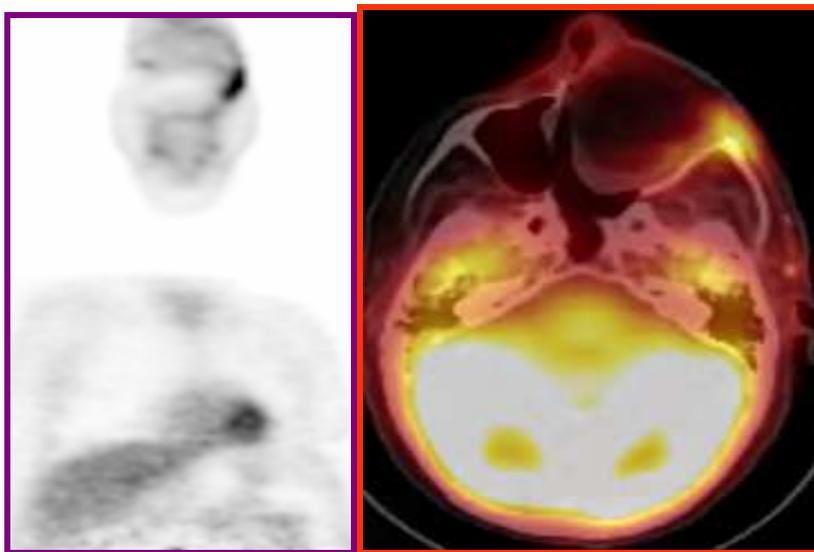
Re-staging of head and neck tumour. The patient is a 72-year-old male with adenopathy in an adenocarcinoma of the left nasal cavity with extension into the orbital region that was surgically operated. 6 weeks later, the tests reveal a FDG-uptake area on the anterior region of the left zygomatic arch, compatible with persistence of viable tumour.
